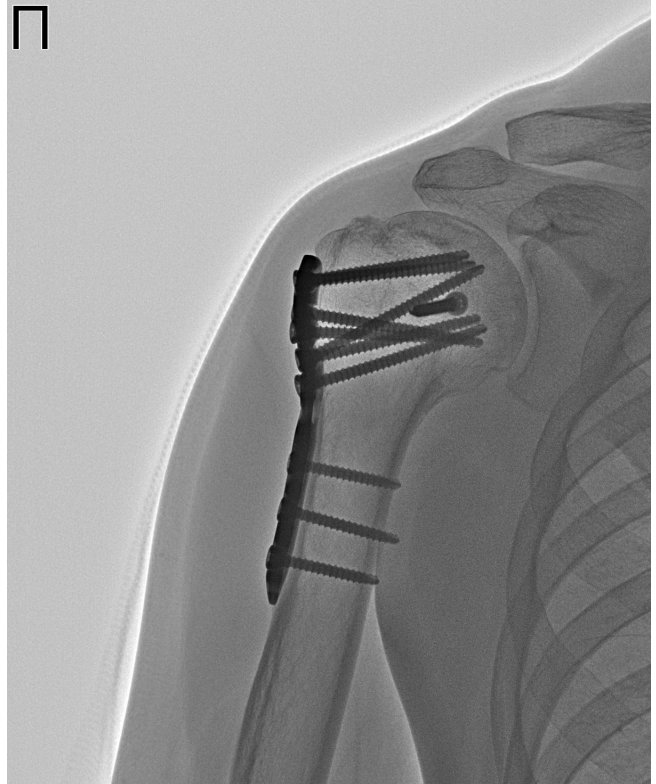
X-ray of the right shoulder joint 12 months after surgery
